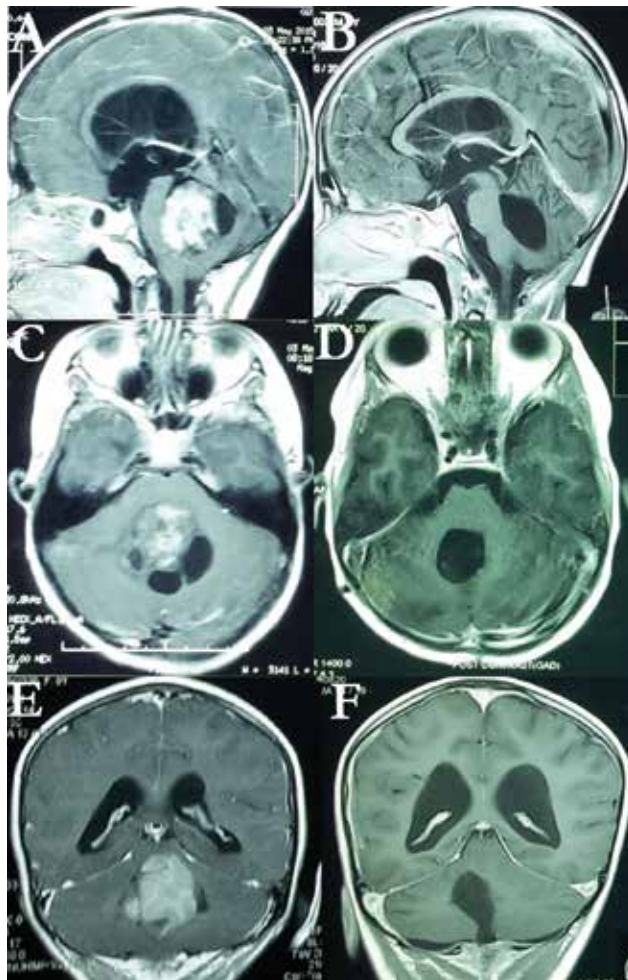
Preoperative contrast enhanced MRI in sagittal (A), axial (C) and coronal (E) planes and 1 year post-operative contrast enhanced MRI following radiotherapy in sagittal (B), axial (D) and coronal (F) planes of a 9 years old boy.
